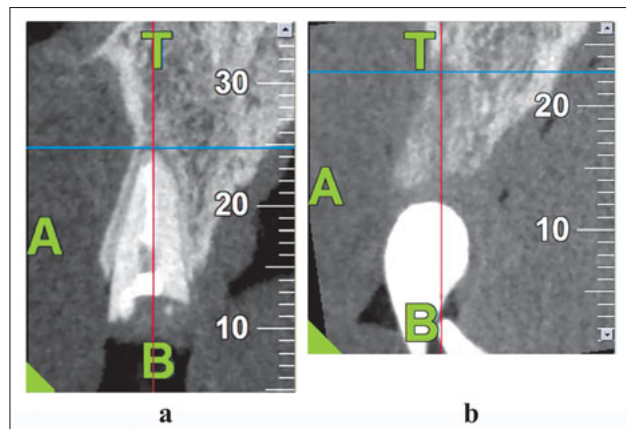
CBCT scans: (a) Before tooth extraction; (b) 6 months after tooth extraction with oval pontics provisional restoration.
